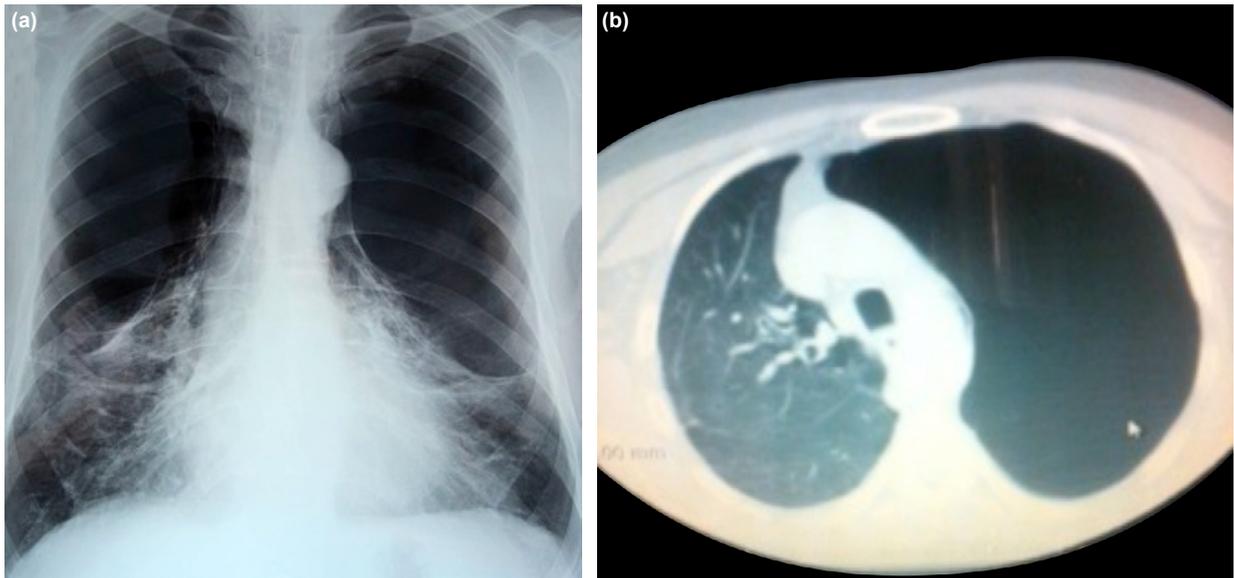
(a) On posteroanterior chest x-ray, a marked increase in aeration, including the upper and middle zones, especially in both lungs, is seen. (b) In thorax CT; a giant bulla is seen in the apical region on both sides, covering more than half of the hemithorax and causing atelectasis in the adjacent lung tissue. On the right, it is noteworthy that neighboring lung tissue is not emphysematous.
